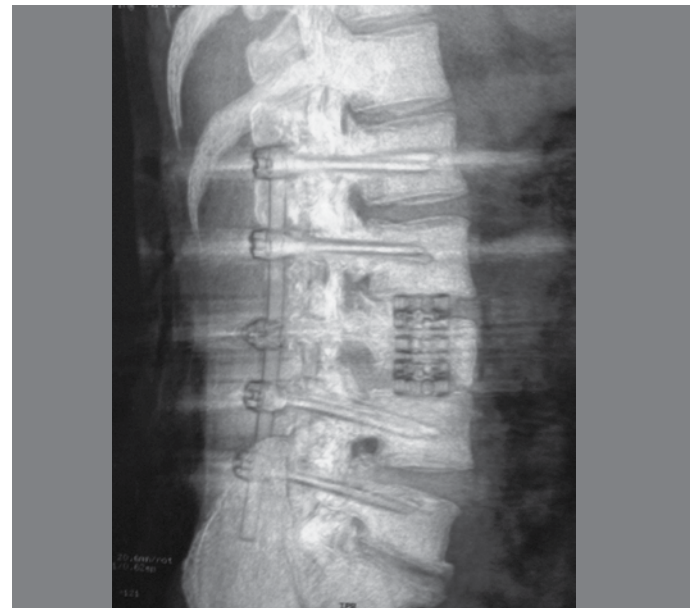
Postsurgical CT.
